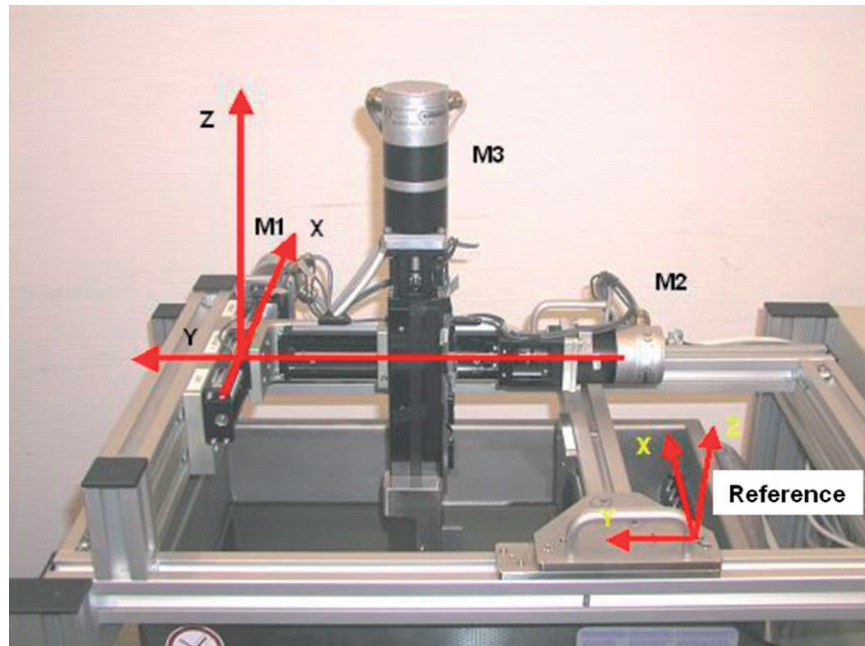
Stepper motor device for verification of the ultrasound probe. The three motors move the test probe along the x-, y- and z-axes in relation to the reference to reach the exact point of intersection.
